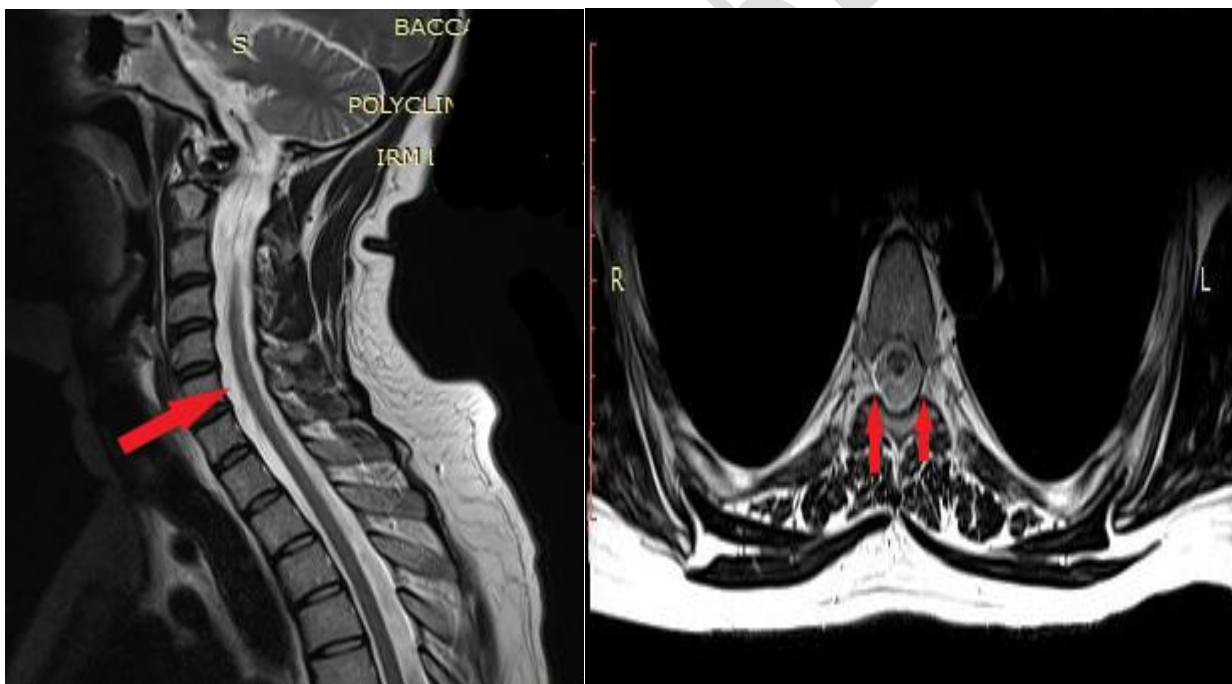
Spinal angio-MRI showing the cervical and dorsal myelitis.
